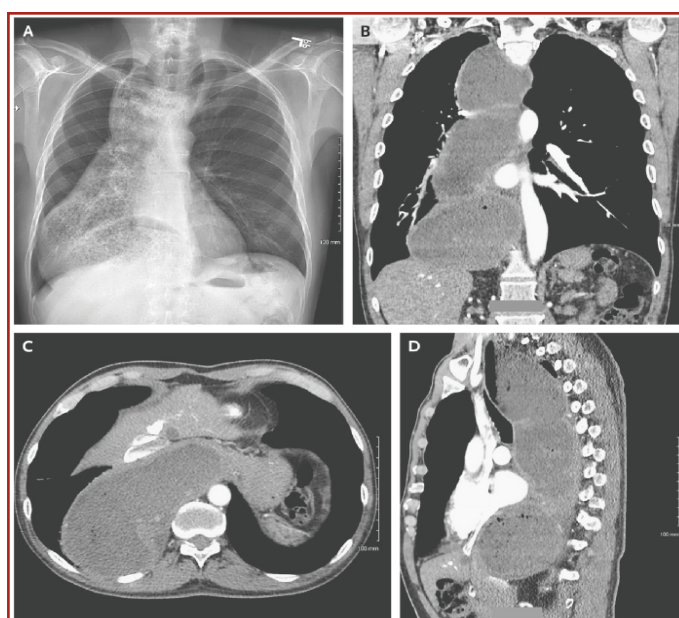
A: X-Thorax; B: Thoracal CT-scan, C: Transverse section, D: Sagittal section.
